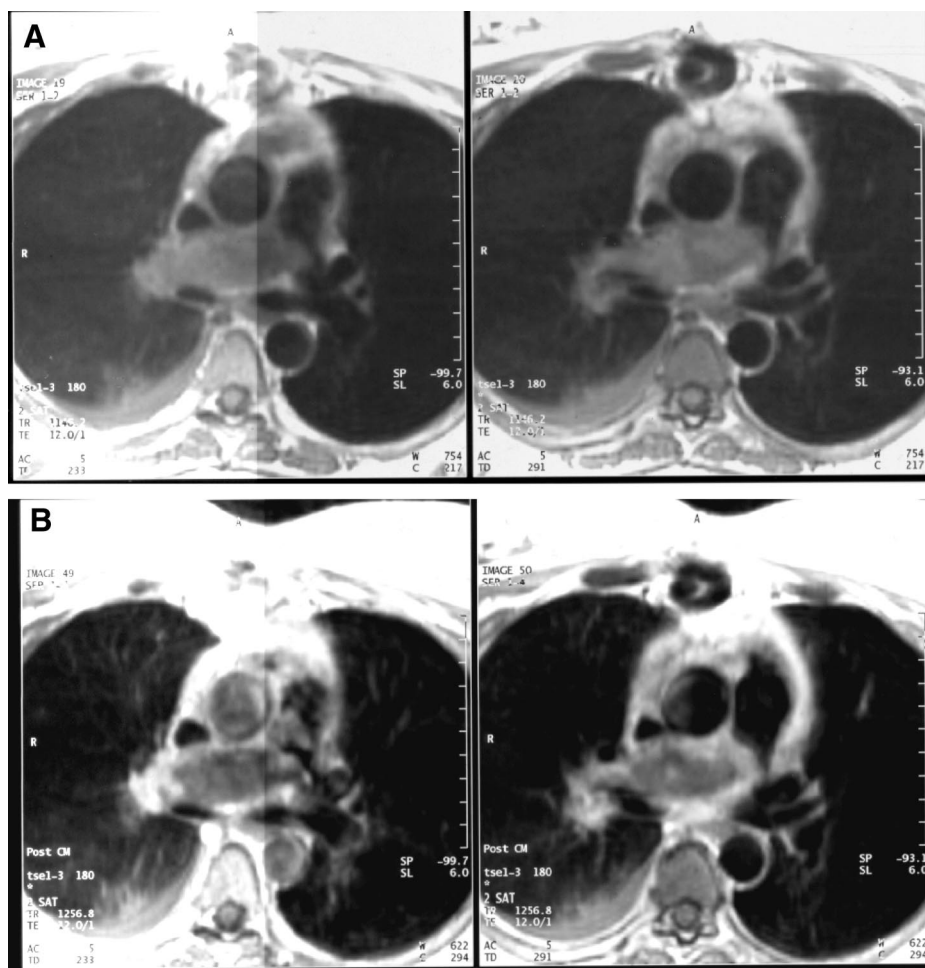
A, MRI performed 4 weeks later because of failure of anticoagulation. T1-weighted images show intermediate heterogeneous signal intensity in right pulmonary artery with irregular margins and superior vena cava infiltration (arrow). Right pleural effusion appears (arrow head). B, After contrast administration: the lesion seems heterogeneous with large central necrosis. Signal of peripheral zone is enhanced by contrast.
